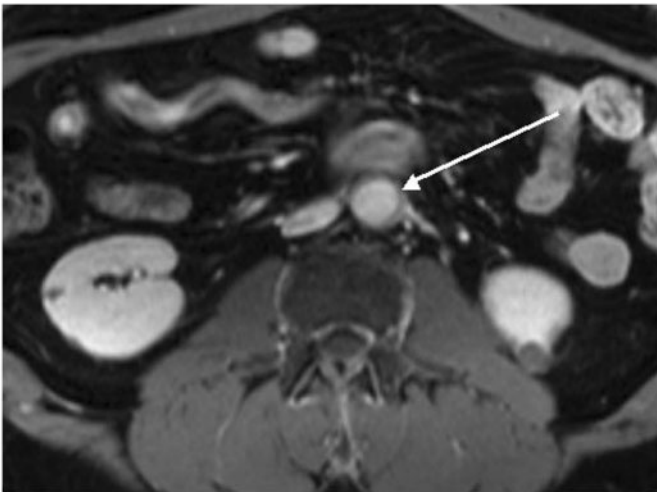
Abdominal MRI 4 months after initiation of MMF and glucocorticoid treatment showing regression of the periaortic mass to a minimal extent. Inferior caval vein and left ureter are almost free of surrounding tissue (one section distal in comparison with Fig. 1 due to technical reasons). Please note the scar tissue in both the figures after surgery for a questionable abdominal aortic aneurysm.
